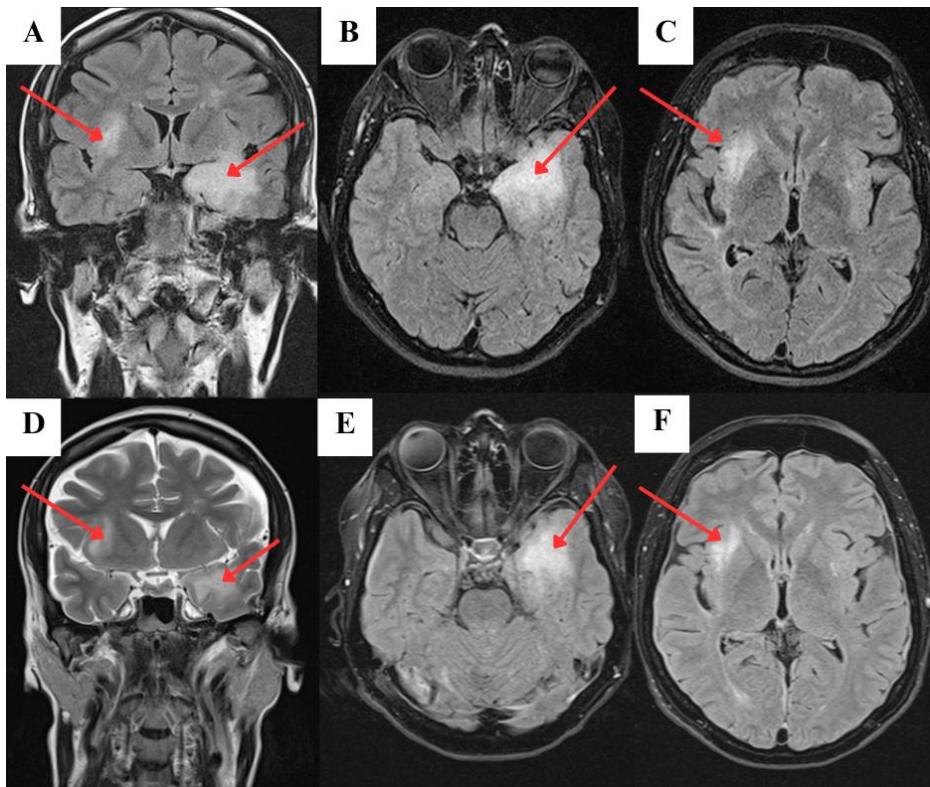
Head magnetic resonance imaging (MRI) scans; A–C – MRI upon the admission showing diffuse lesions surrounded by edema without contrast enhancement, hyperintense in T2-weighted and hypointense in T1-weighted images, localized primarily in the medial part of the right temporal lobe; D–F – follow-up MRI after 2 weeks of treatment showing regression of the inflammatory lesions
